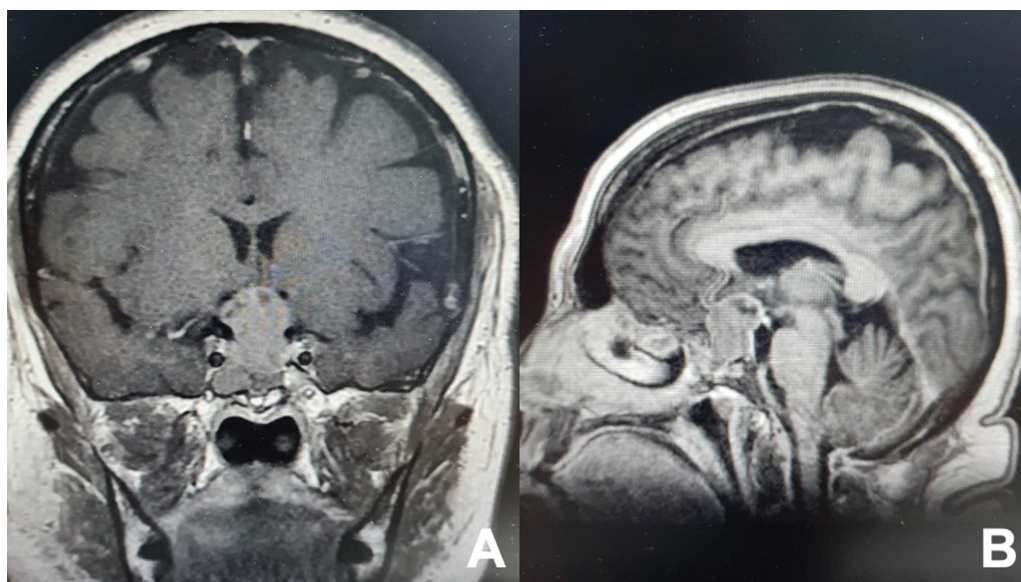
Preoperative imaging studies. (A) Coronal preoperative magnetic resonance imaging (MRI) scan indicating a well-defined mass lesion in the sellar region with suprasellar extension, measuring $25 \times 18 \times 20$ mm, and compressing the optic chiasm. (B) Sagittal reconstruction of a head MRI showing suprasellar extension and compression of the optic chiasm.
